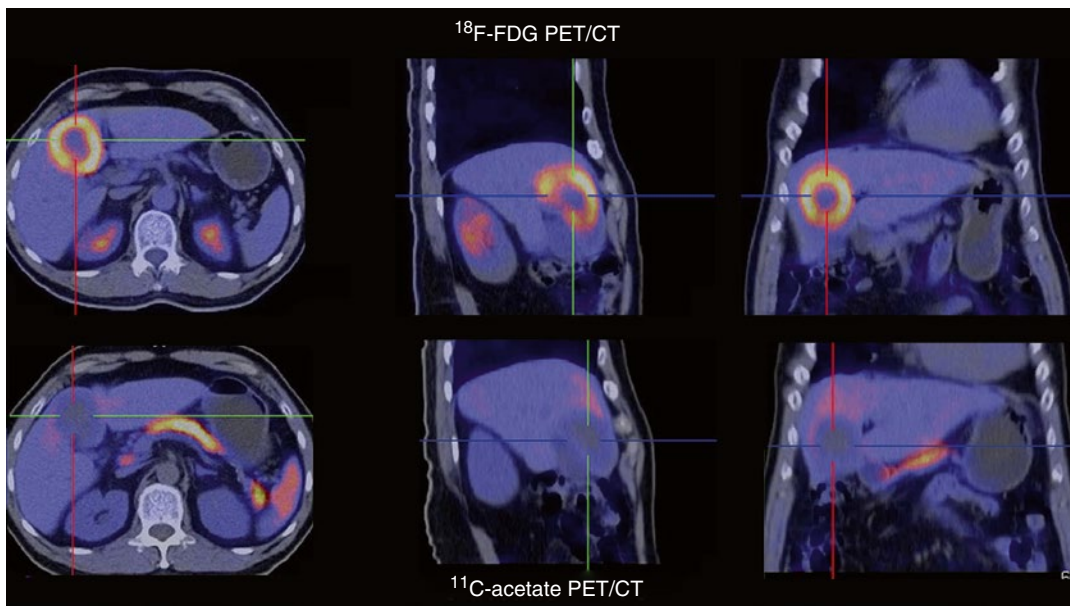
Dual-tracer PET/CT of a cholangiocarcinoma shows markedly increased ^{18}F -FDG metabolism (*upper row*) but no abnormal ^{11}C -acetate activity (*lower row*)
